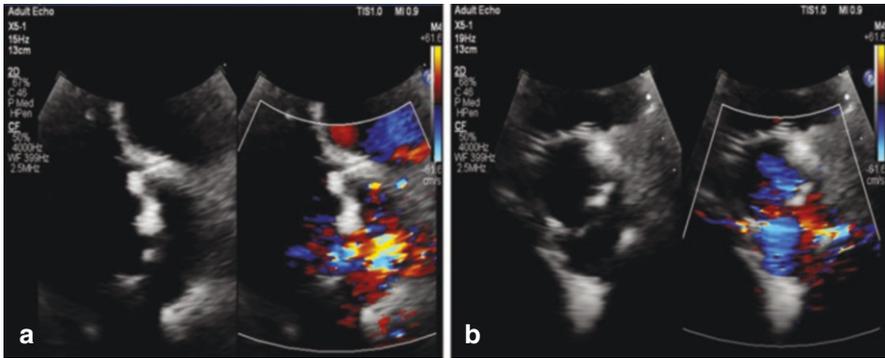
Preprocedural transthoracic echocardiography. (a) Accelerated flow across the aortic valve consistent with severe AS in the parasternal long-axis, (b) short-axis view of aortic valve
